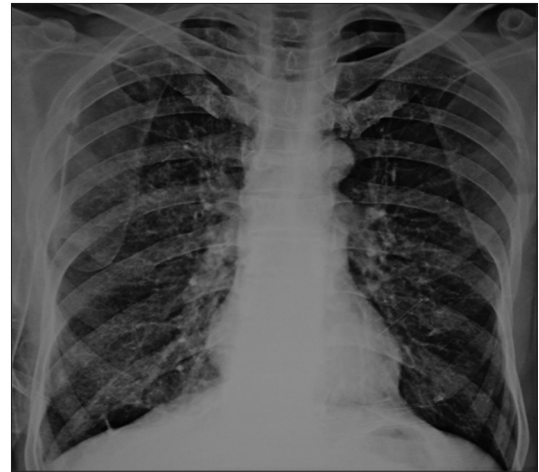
Chest X-ray showing expanded lung and resolution of pulmonary edema
